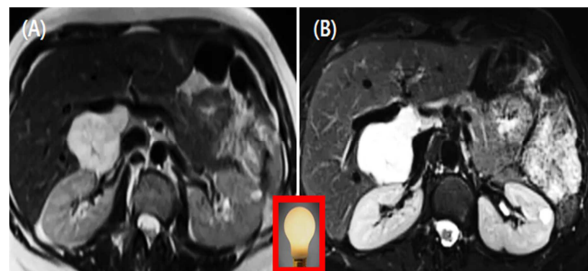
MRI of Hepatic Hemangioma. (A) T2 weighted image, (B) T2 weighted image enhanced
